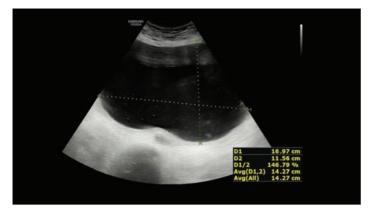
Ultrasound image showing a large abdominopelvic thin walled cystic lesion with multiple internal echoes, thin incomplete septations and no solid areas.
